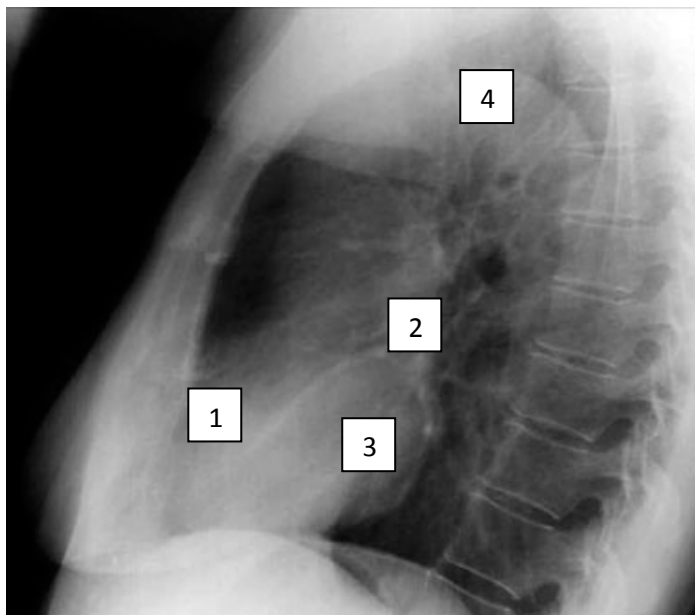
The chest radiograph in the left lateral projection. 1 –the right ventriculus, 2 - the left atrium, 3 - left ventriculus, 4 - the aorta arch
